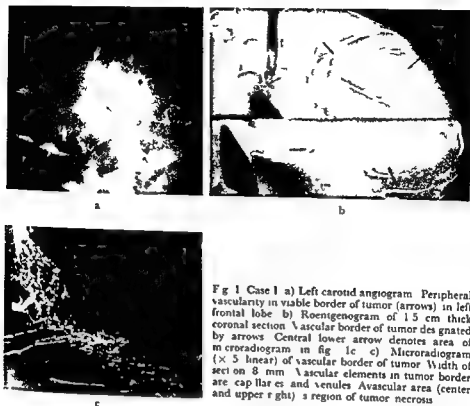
Case 1 a) Left carotid angiogram. Peripheral vascularity in viable border of tumor (arrows) in left frontal lobe. b) Roentgenogram of 1.5 cm thick coronal section. Vascular border of tumor designated by arrows. Central lower arrow denotes area of necrosis. c) Microradiogram ($\times 5$ linear) of vascular border of tumor. Width of section 8 mm. Vascular elements in tumor border are capillaries and venules. Avascular area (center and upper right) is region of tumor necrosis.
